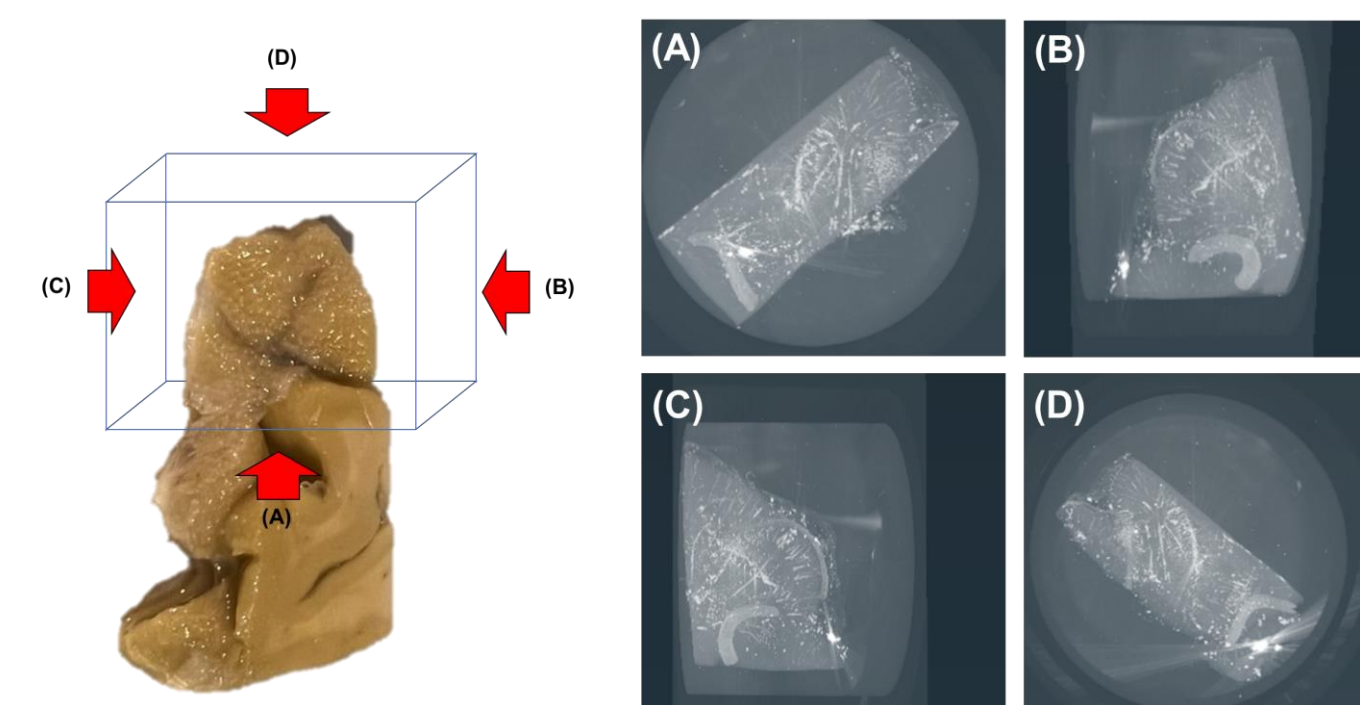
X-ray phase-contrast microtomography. Arrows in left panel (A), (B), (C), and (D) represent orientation of 3D phase contrast CT images. Right panel is an example of merged images. This view can be observed in a 3D mode.
